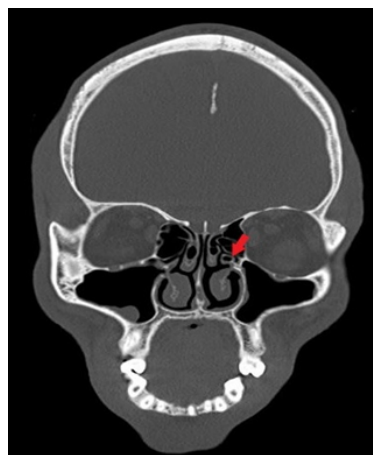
(Original) Reformatted Coronal CT images of the skull (bone window) showing pneumatization of the left uncinata process
